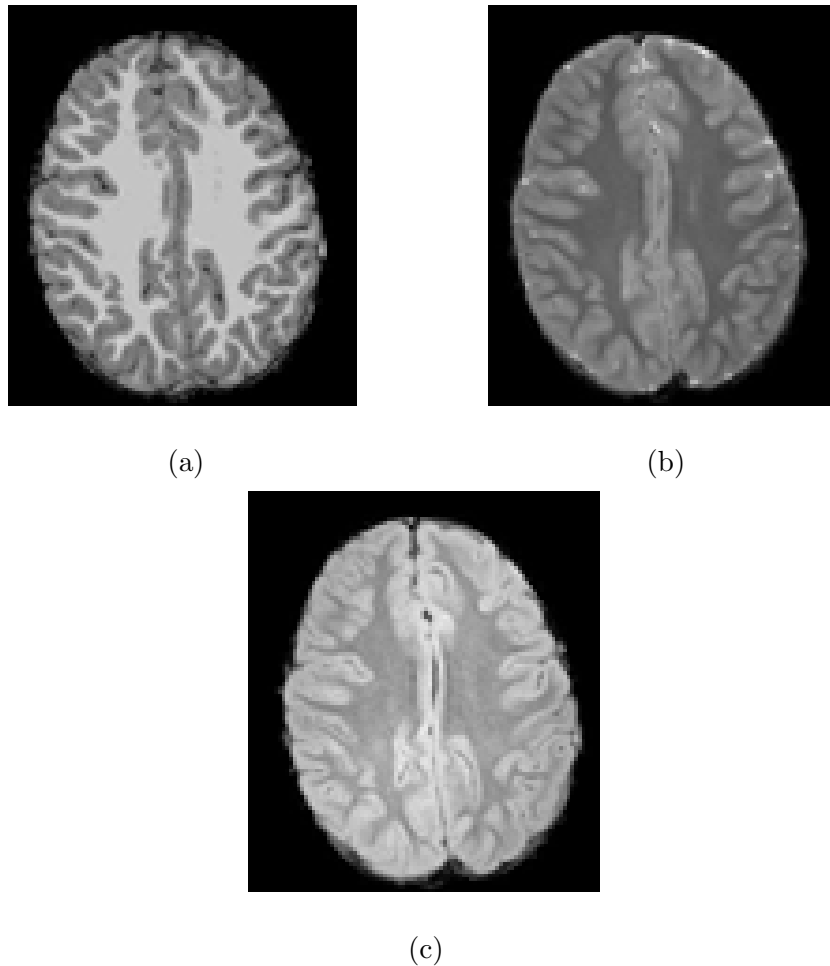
Axial slice of (a) T1-weighted and registered (b) T2-weighted and (c) FLAIR Volumes
